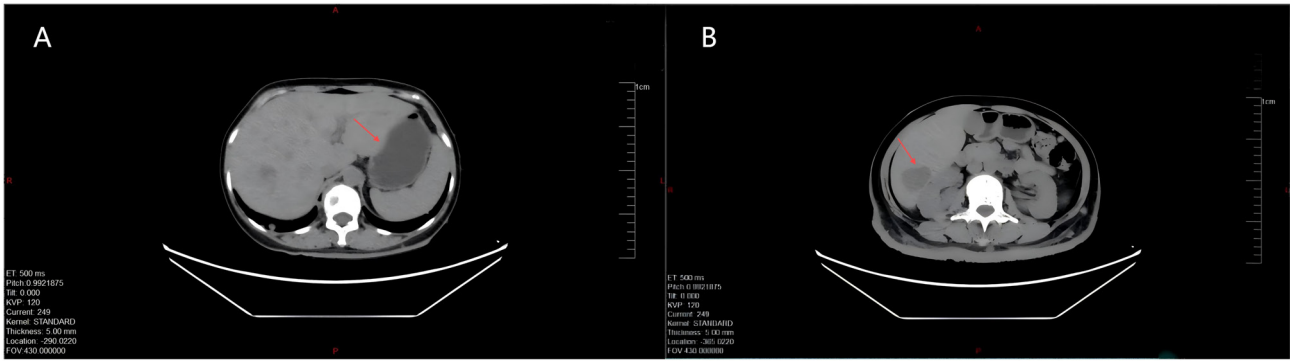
Multiple slightly hypodense shadows shown in the liver on abdominal CT (arrows indicate the liver metastasis focus). (A) Level of the left lobe of the liver. (B) Level above the renal hilum.
